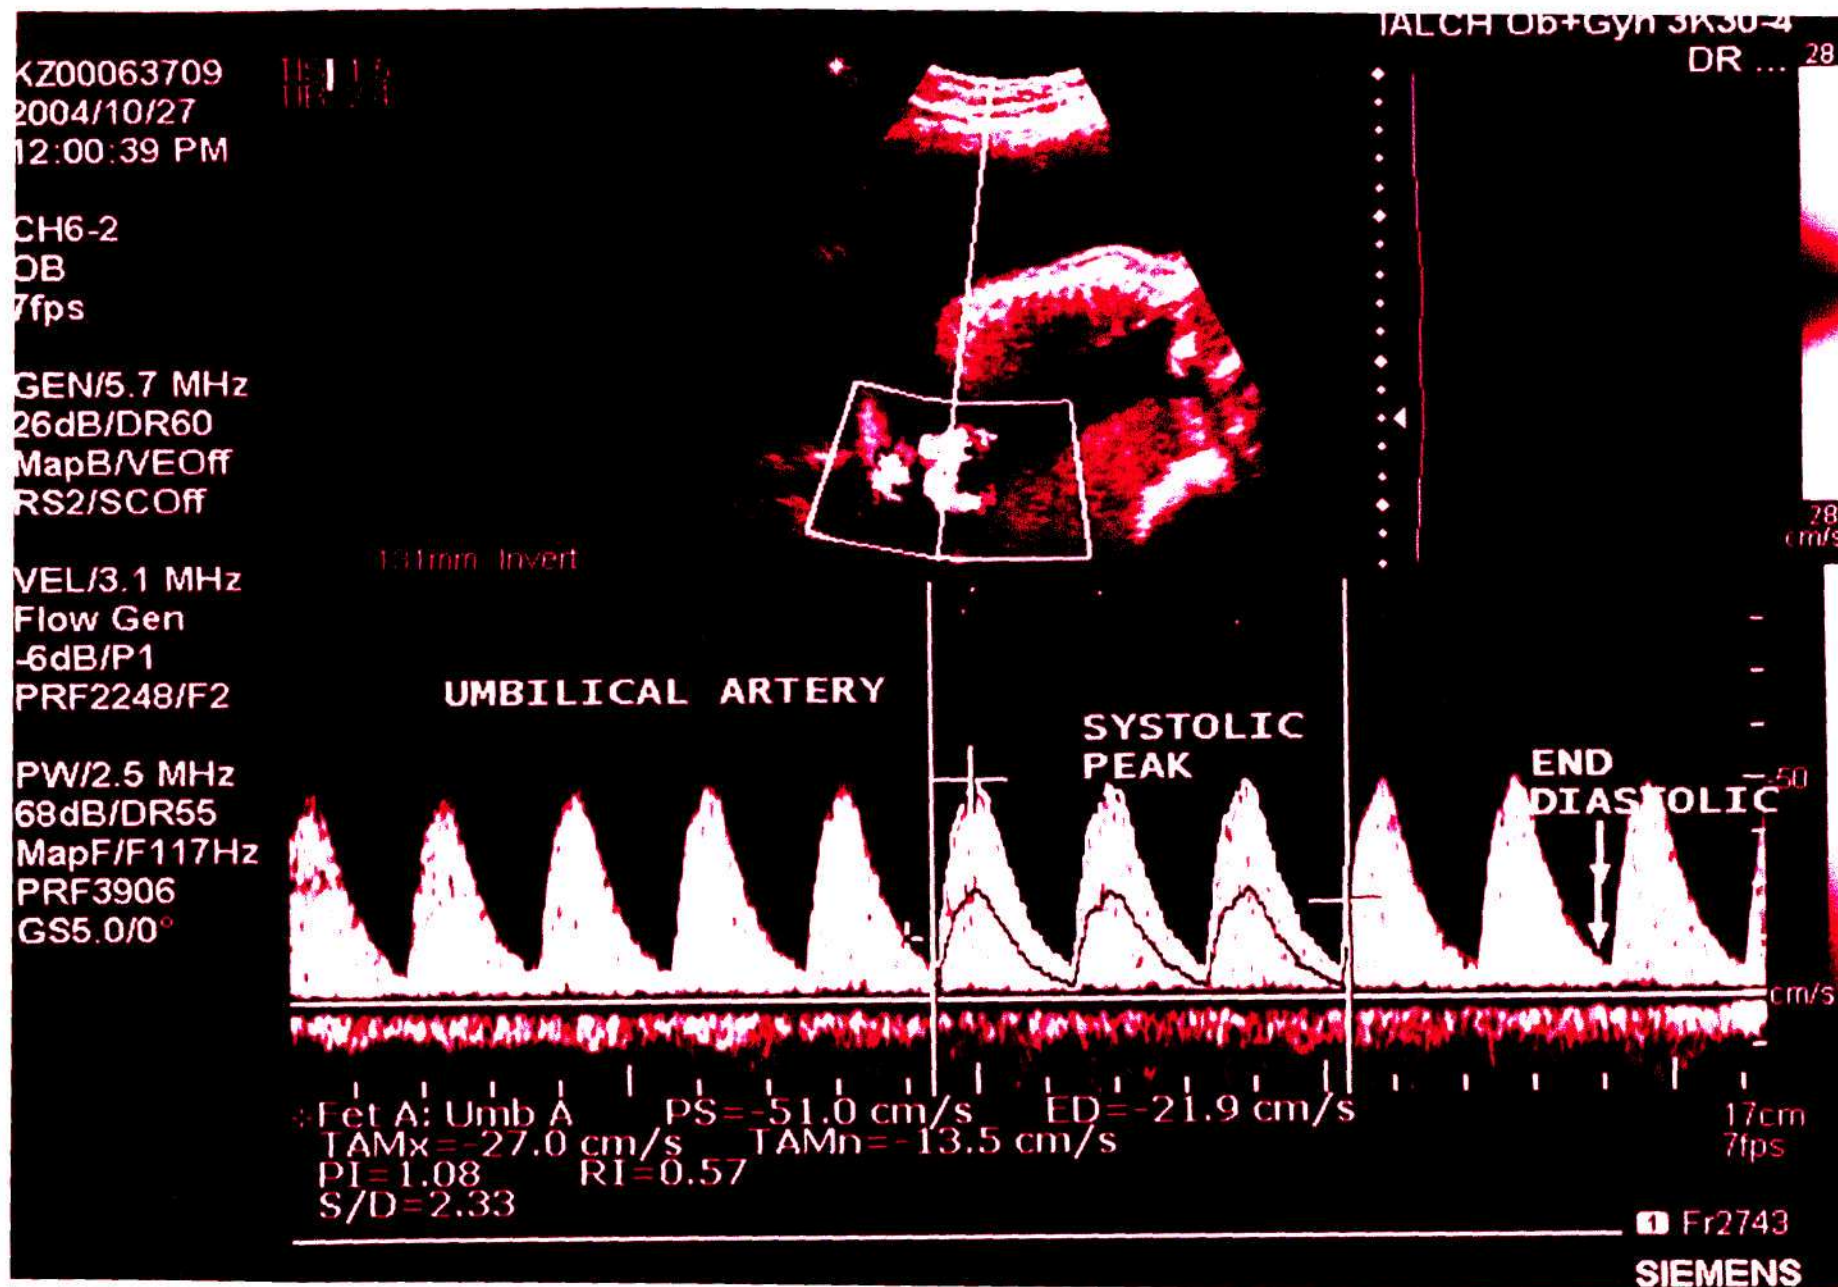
Umbilical artery Doppler velocimetry (Normal)
